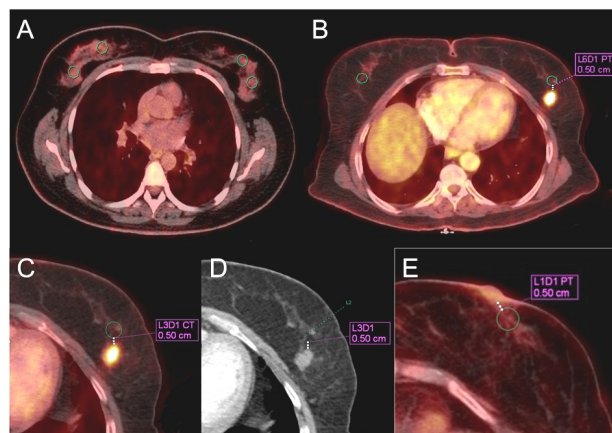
Examples of SUV measurement using a standard 1.5 cm³ VOI. For BPU in the CG, SUV was measured at two locations in both healthy breasts, the two-quadrant that are appropriate (A) and both of the healthy breasts, 0.5 cm from the areola in retroareolar region (E). For BC, 0.5 cm from the tumor in the same quadrant (B-D), The contralateral quadrant of the ipsilateral breast (B).
